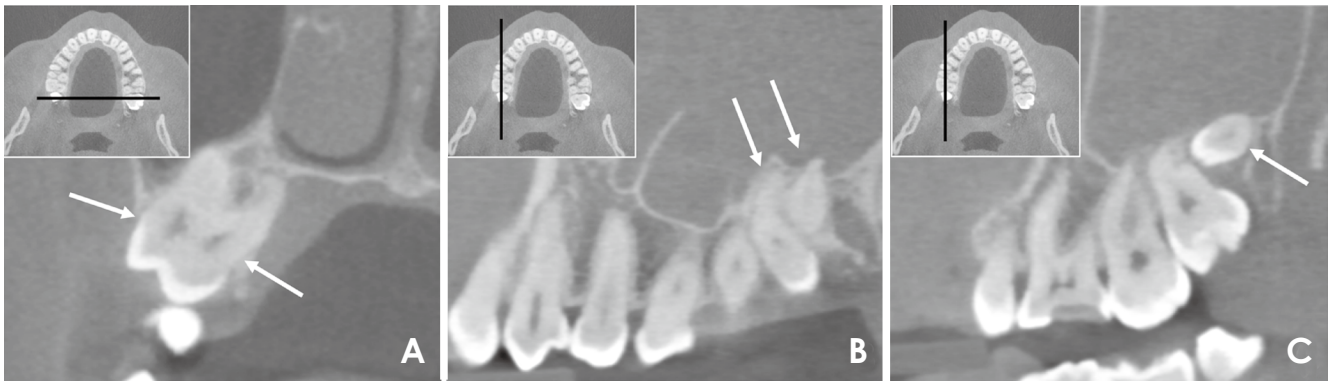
A. Coronal cone-beam computed tomographic (CBCT) reconstructed image of the patient’s right maxillary quadrant, with partially fused roots and fused crowns of the third and fourth molars. B. A sagittal reconstruction CBCT image shows the partially fused roots and fused crowns of the third and fourth molars. C. A sagittal reconstruction CBCT image reveals the fifth molar.
